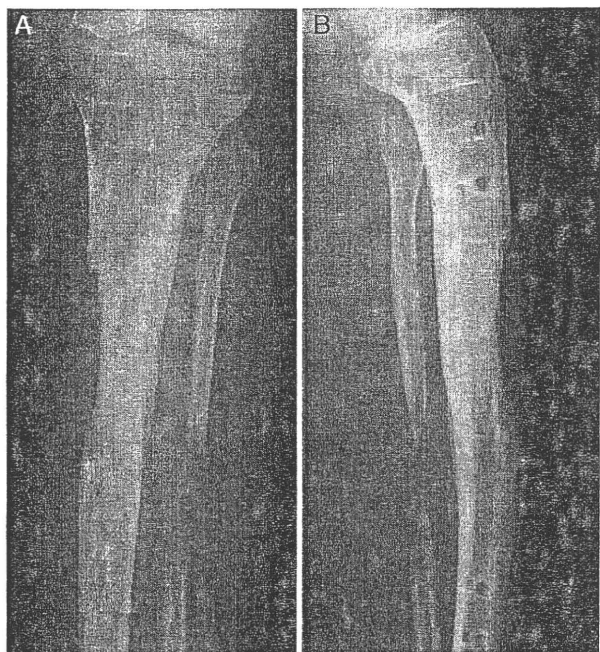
Anteroposterior (A) and lateral (B) radiographs of the left tibia of an 18-year-old man with hypochondroplasia (case 14) just after removal of the pins. Callus formation was predominant posterolaterally and extremely poor at the anteromedial aspect of the tibia.
